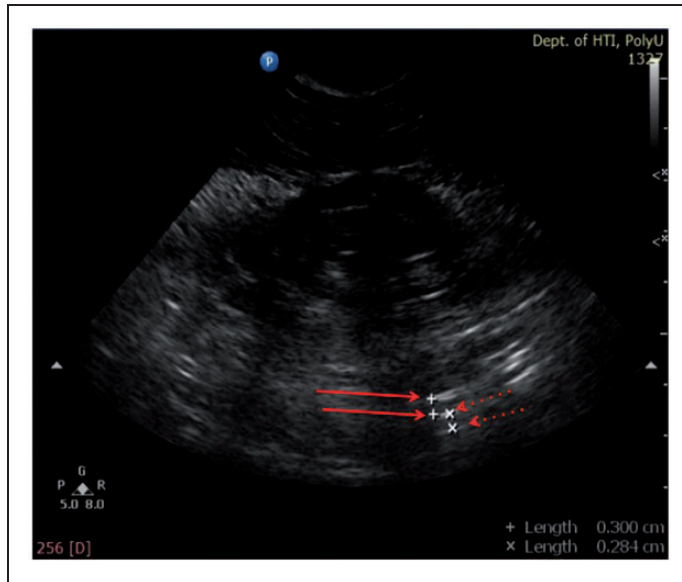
Representative grey-scale sonogram from a healthy Chinese male young adult, showing measurement of mesenteric fat thickness: the periphery of mesenteric leaves and mesenteric fat thickness were measured using callipers, and defined as the perpendicular distance between two successive mesenteric leaves. Two layers of mesenteric leaf thickness were determined by the distance between two '+' markers (solid line arrow) and between two 'x' markers (dotted line arrow), corresponding to 3 mm and 2.84 mm, respectively, in the present figure
